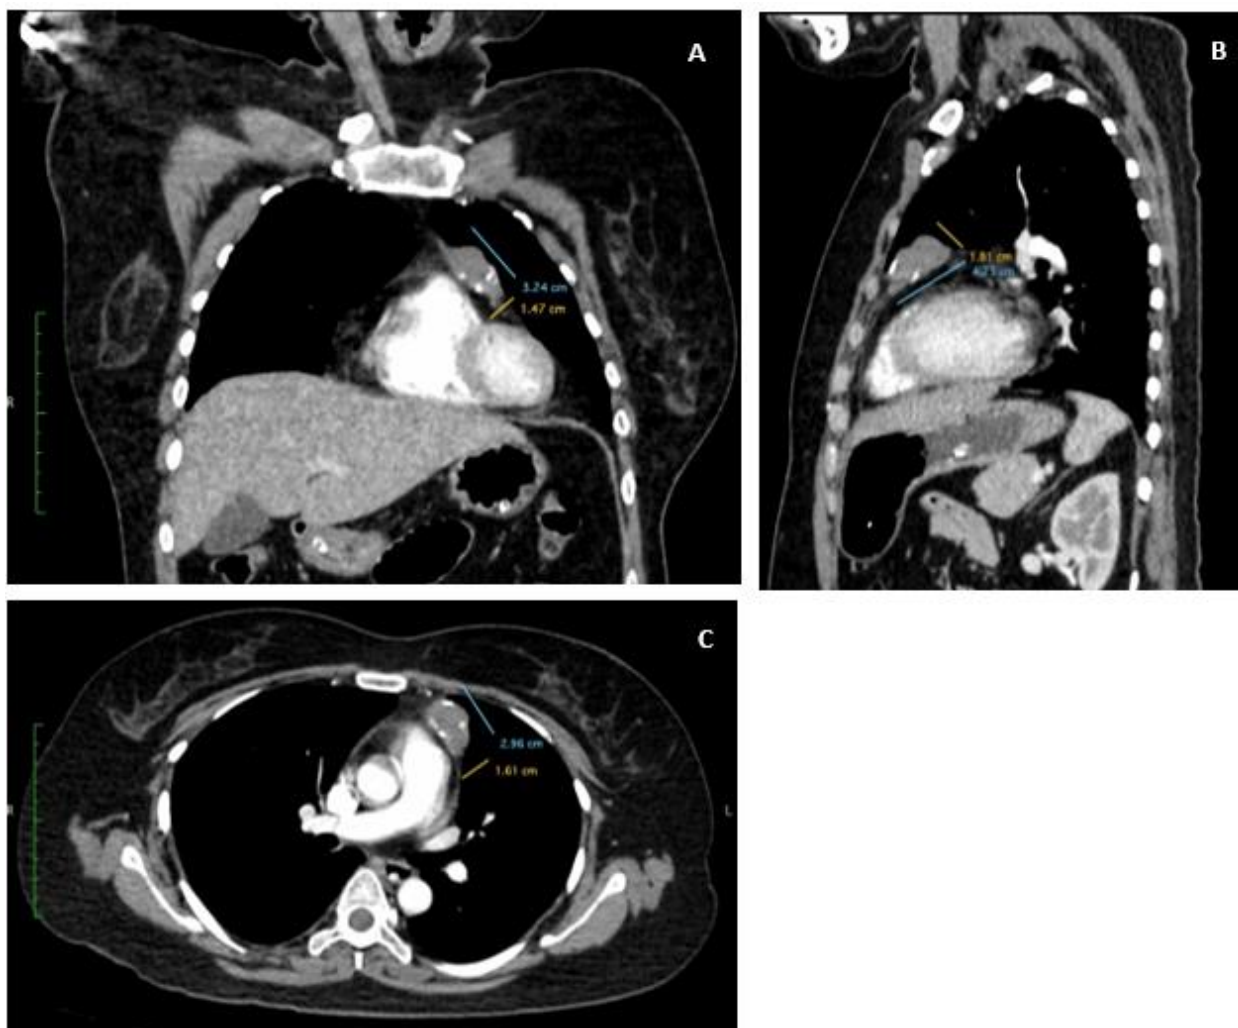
A (coronal view) B (sagittal view) C (axial view): Contrast-enhanced CT scan of the neck and thorax demonstrating a calcified lobulated soft tissue mass occupying the anterior mediastinum (representing the thymoma). There are no fatty infiltration or intra-thoracic lymphadenopathies.
